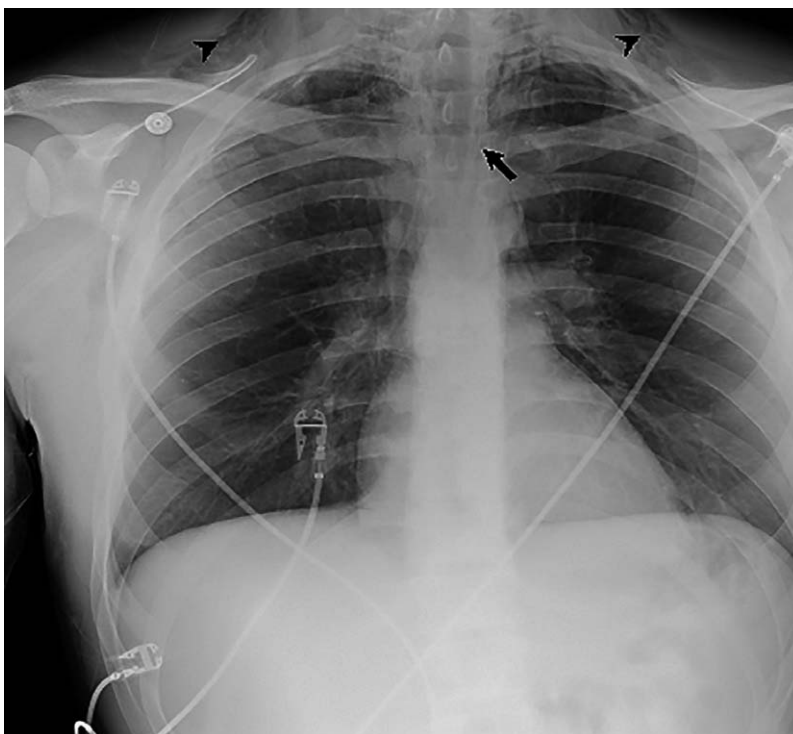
Chest radiography showing pneumomediastinum (long arrow) and subcutaneous emphysema of the neck and upper area of the chest (short arrows).
